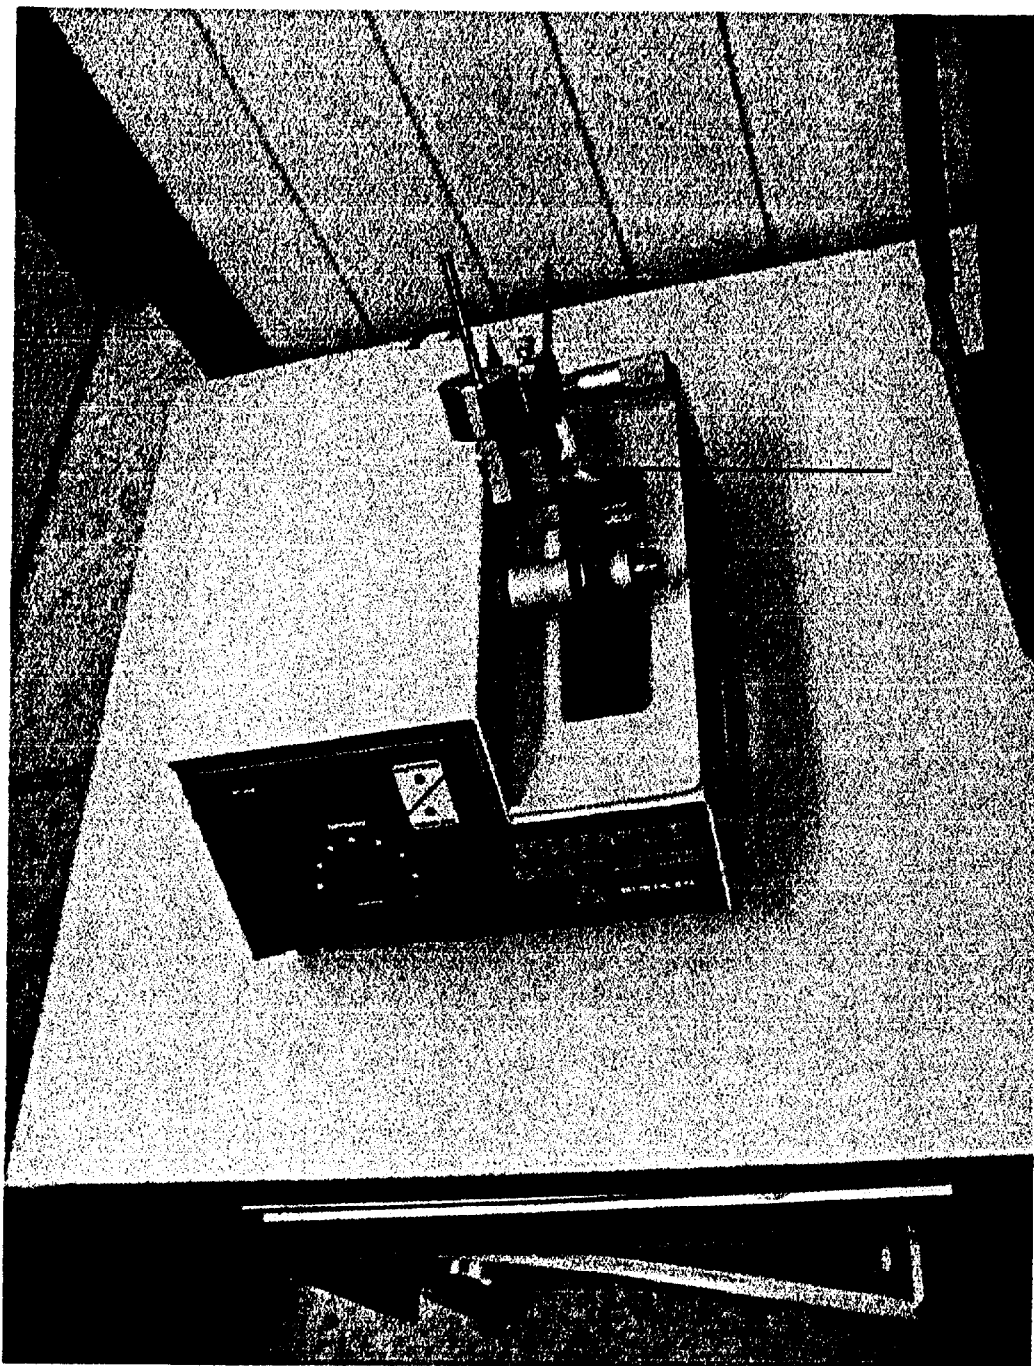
Using of low speed ISOMET saw for cutting of tooth samples in order to allow for contribution from possible x-ray diagnostic examinations. The arrow shows the tooth that should be cut.
